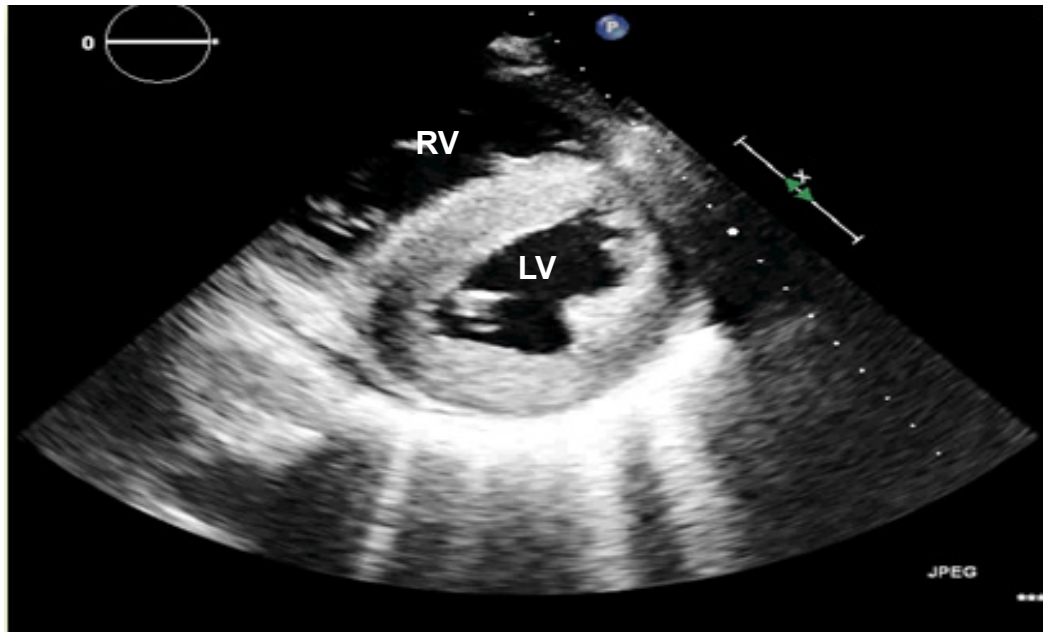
Echocardiogram cross parasternal projection demonstrating increased thickness and appearance in sparkling granular myocardial the left ventricle. LV: left ventricle; RV: right ventricle.
